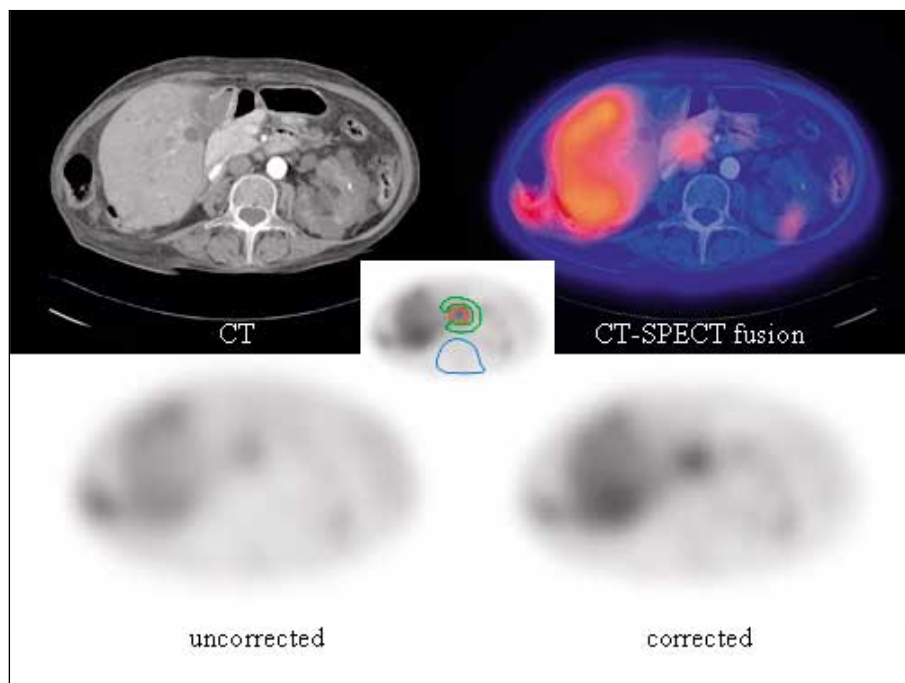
Neuroendocrine tumour of pancreatic head. Corresponding transaxial slices from CT, CT/indium-111-pentetreotide-SPECT fusion as well as SPECT without and with attenuation correction are shown. The tumour was not visible on the CT scan. However, biopsy during endoscopy confirmed its presence at that location. SPECT images are calibrated to their own maxima. The intensity in the centre of the image increased after attenuation correction, meanwhile the structures located at the periphery remained equal. In this case, $TBAC/TBNAC_{\text{vertebral}}$ is 1.52. On the picture inserted in the centre, the ROI over the focus, the perifocal ROI and the vertebral ROI are shown.
